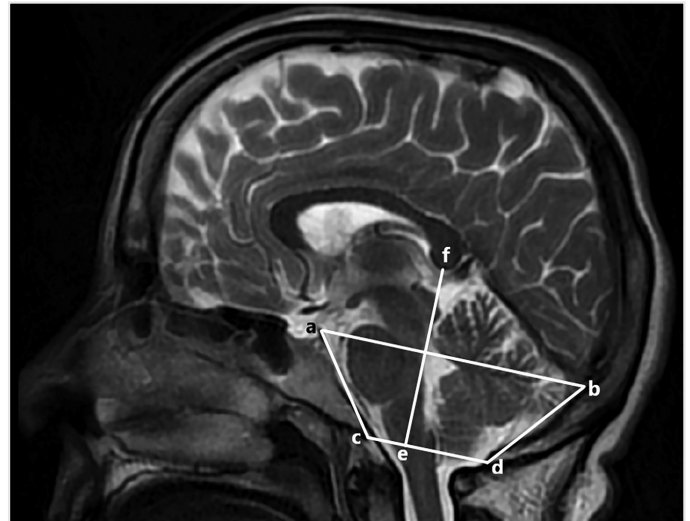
Posterior fossa measurement method made on mid-sagittal T2-weighted MRI of a healthy case
